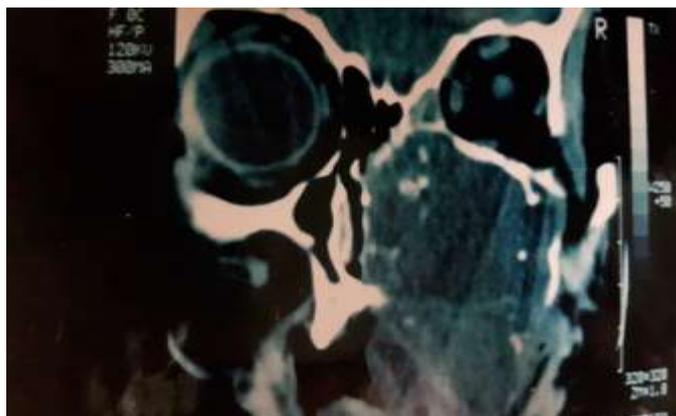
CT scan of same patient in fig. 7
